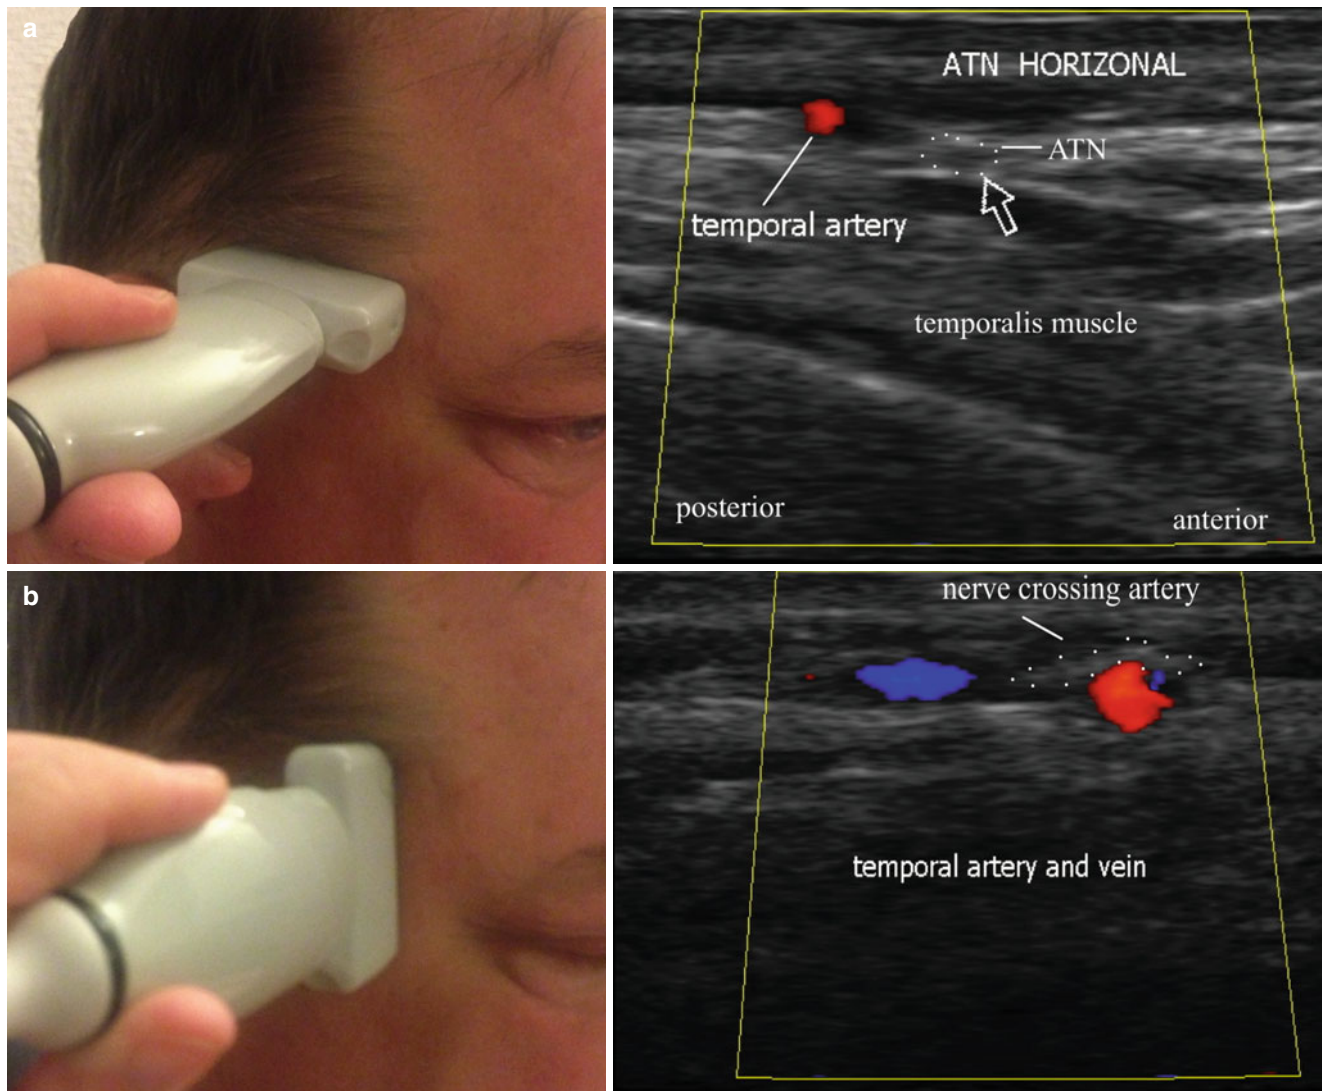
Ultrasound evaluation of the auriculotemporal nerve. (a) Horizontal evaluation; (b) Vertical evaluation (Images courtesy of Andrea Trescot, MD)
